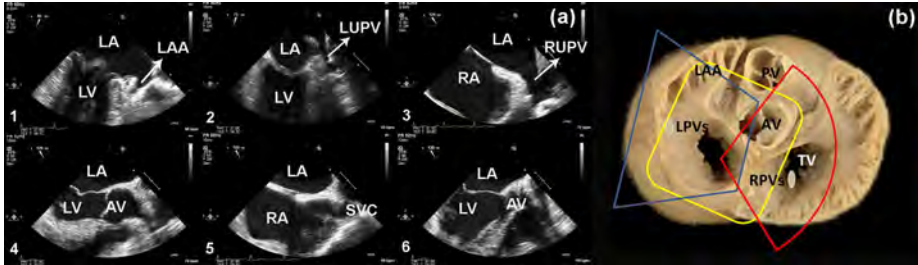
A, two-dimensional transoesophageal echocardiography reference views of the 6-step image acquisition protocol. 1, the mitral commissural view; 2, the superior commissural view including the left upper pulmonary vein; 3, the modified bicaval view including the right upper pulmonary vein; 4, the aortic valve long axis view; 5, the midpoint view between the aortic valve long axis and bicaval views; 6, Further left to the aortic valve long axis view. B, cardiac structures acquired in the 3D datasets of Step 1 (yellow), Step 2 (blue) and Step 3 (red). The grey areas represent the area of the pulmonary vein ostia projected to the cross-section of the anatomical view. AV, aortic valve; LA, left atrium; LAA, left atrial appendage; LPVs, left pulmonary veins; LUPV, left upper pulmonary vein; LV, left ventricle; MV, mitral valve; PV, pulmonary valve; RA, right atrium; RPVs, right pulmonary veins; RUPV, right upper pulmonary vein; SVC, superior vena cava; TV, tricuspid valve
